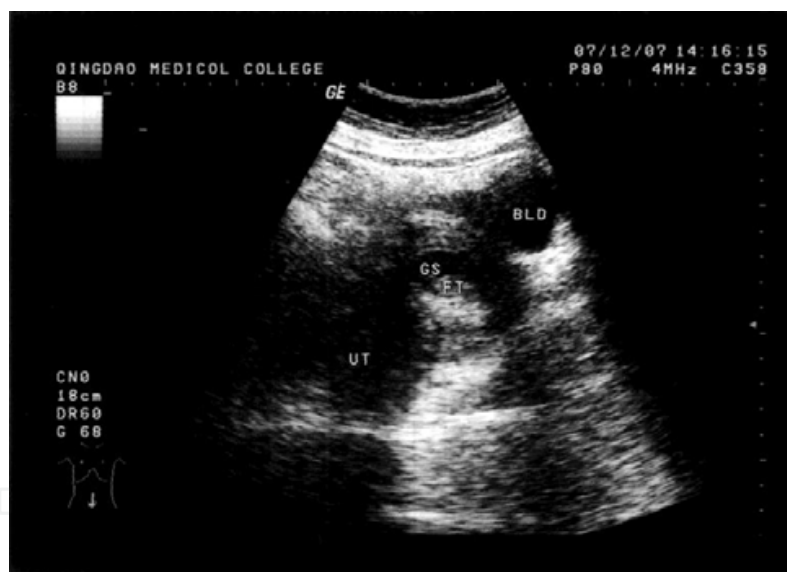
Transabdominal ultrasound image of the cervical pregnancy. A 45-year-old woman, gravida 3, para 1 was admitted at 7 weeks and 5 days' gestation, presenting with a small amount of bloody vaginal discharge. Transabdominal sonography revealed normal-sized uterus with empty cavity. The gestational sac with a viable fetus is evident under the closed internal os. The β -hCG level was 59,313 mIU/L. UT: uterus; BLD: bladder; GS: gestational sac; FT: fetus
